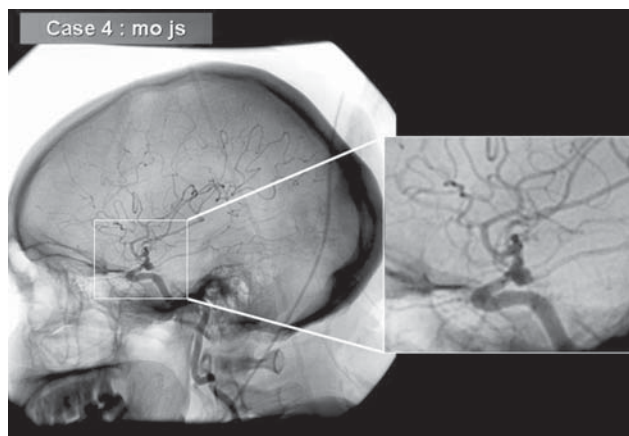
A 61 year-old woman presented with severe headache. CT revealed subarachnoid hemorrhage. She was assessed as Grade 2 SAH. A diagnostic 3D rotational DSA showed a 9 mm saccular aneurysm in the left posterior cerebral artery
